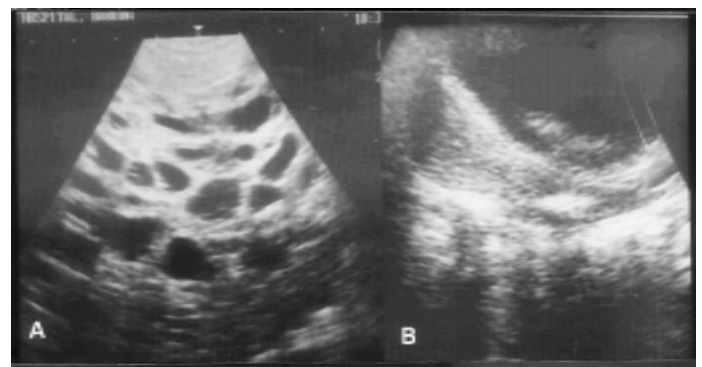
(A) Pelvic sonography showing a bulky uterus completely filled with multiple anechoic cystic spaces and (B) showing normal uterus at follow up sonography.
